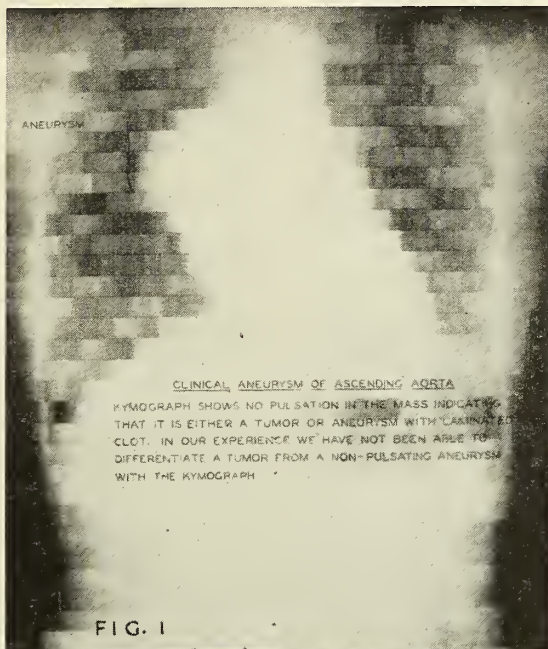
Aneurysm of the Ascending Aorta. The Roentgen kymograph records no pulsation indicating the presence of a laminated clot in the wall.
